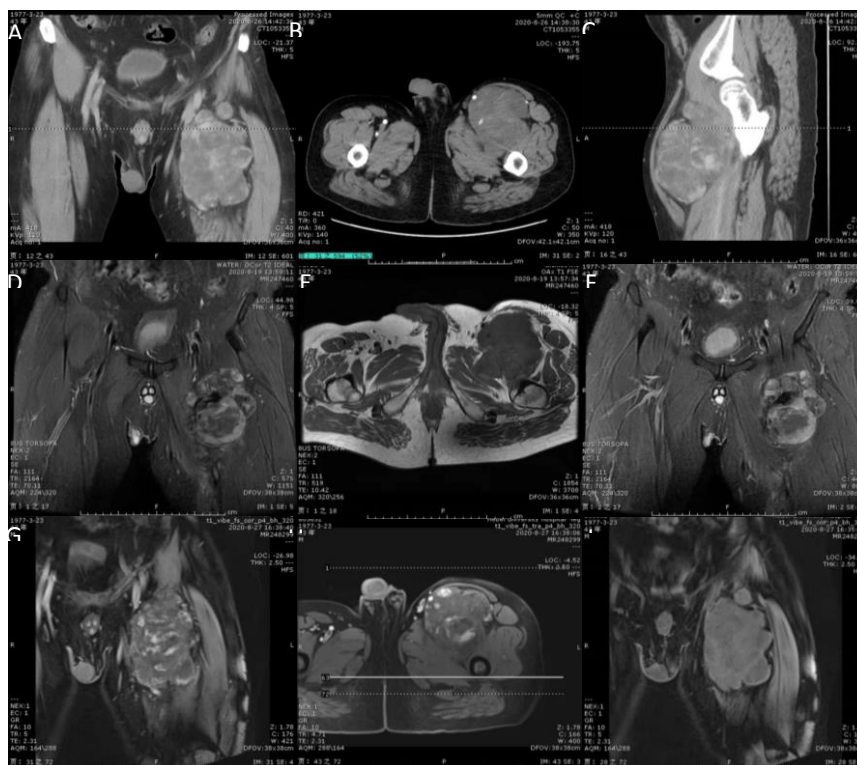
Computed tomography images of case 2A-C: In the soft tissue of the left front thigh, there were massive mixed density shadows with unclear boundaries (dimensions: 10.7cm×8.9cm×13.1cm). The enhancement scan showed obvious heterogeneous enhancement, showing delayed enhancement, and no obvious abnormality in adjacent bone. Magnetic resonance imaging of case 2D-F: In the left femur soft tissue, there were irregular, slightly long and equal T1 and equal and long T2 signal masses, which fused into clusters. The maximum coronal plane was 9.3 cm×10.2 cm. Enhanced magnetic resonance imaging (G-I): An irregular mass with heterogeneous enhancement was found in the soft tissue of the left thigh (dimensions: 10.2 cm×9.0 cm×14.1 cm). Blood vessels can be seen in it, and the adjacent structures are compressed and displaced
